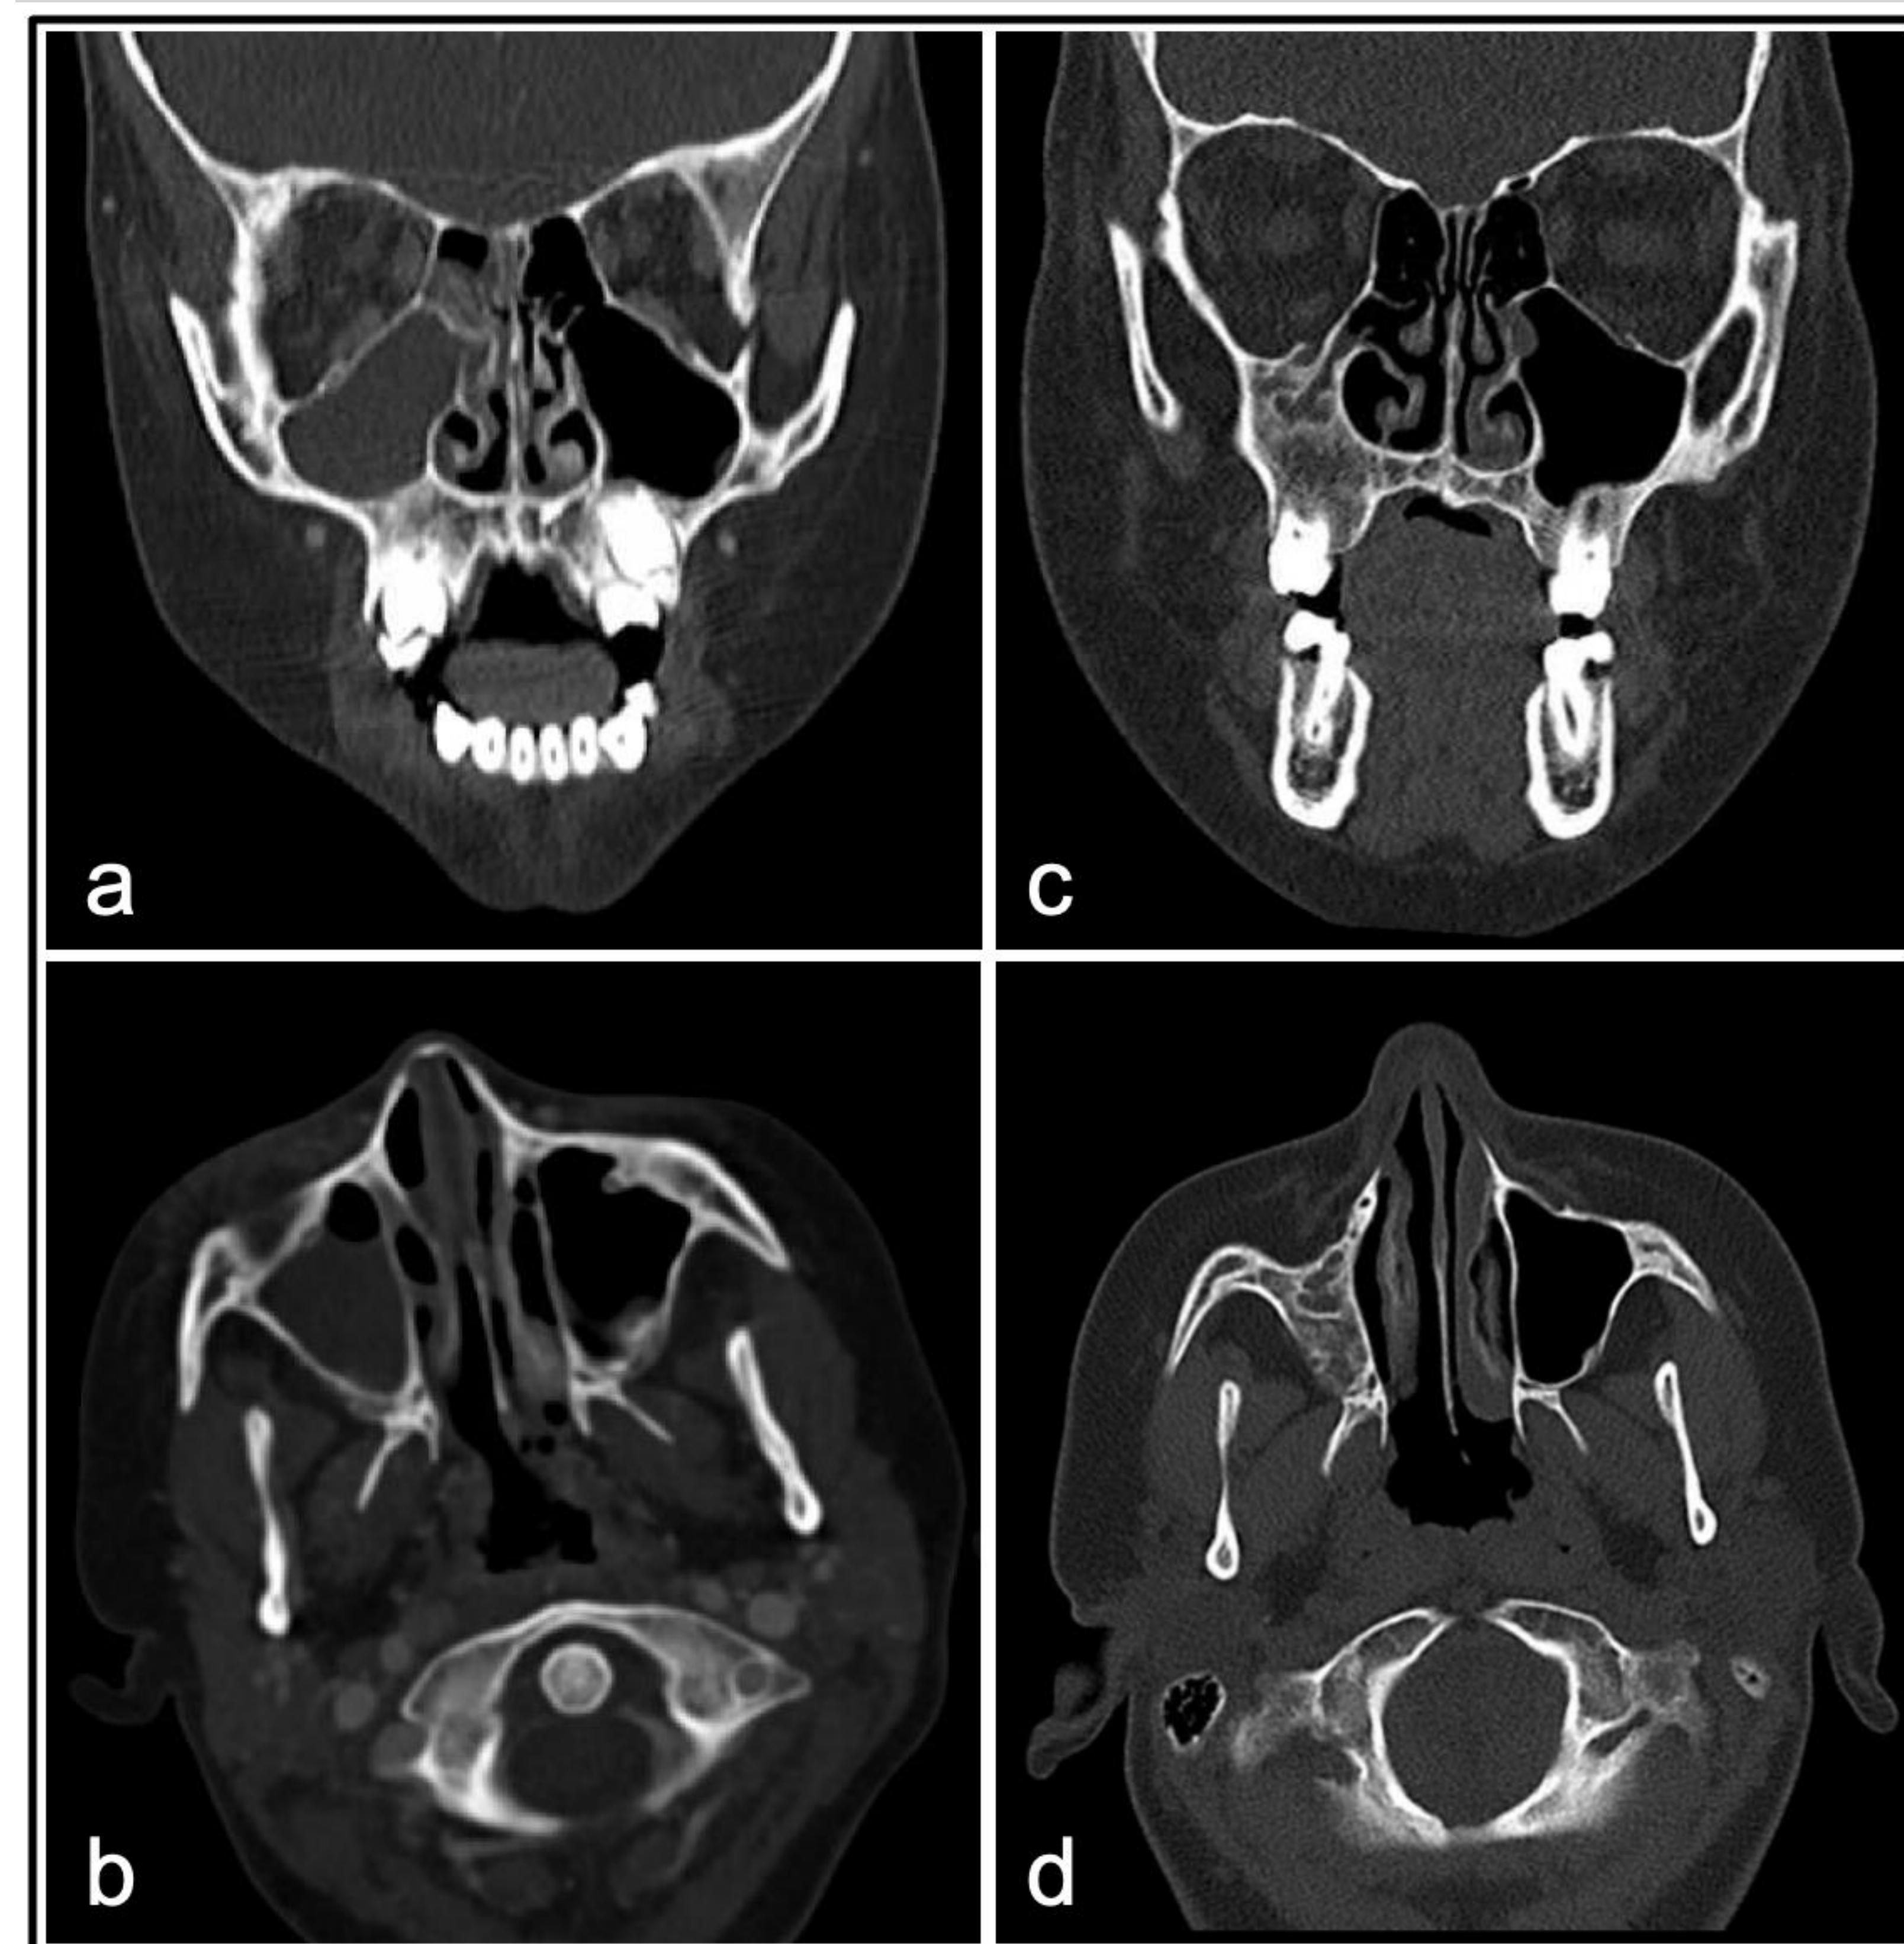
Radiological progression of post-infectious SSS. (a) coronal and (b) axial head CT performed 2/2023. (c) coronal and (d) axial head CT performed 1/2025.
